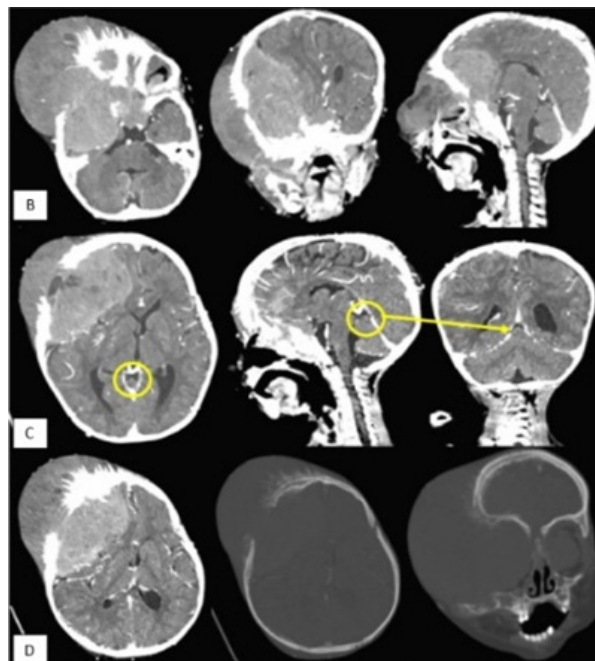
(A) The patient has had lumps in both eyes and the right side of the head since she was 7 months old. Contrast head CT imaging revealed a calcified mass extending from the right orbital into the paranasal sinus and left orbital. (B) It also showed compression of the right cerebral hemisphere in the right fronto-parieto-temporal and suprasellar regions. (D) This was characterized by periosteal reaction, resulting in a hair-on-end appearance in the adjacent bone. (C) Additionally, there is an extension to the pineal gland, measuring approximately 7.4 x 8.1 x 7.8 cm, with slight contrast enhancement.
